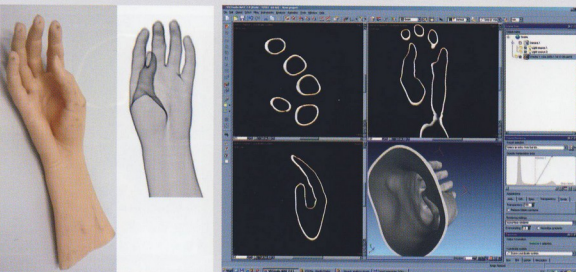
Epithetic hand glove (left), its X-ray scan (middle) and an environment of the VG-Studio Max software with three cross-sections and 3D view of rendered model of the glove.
